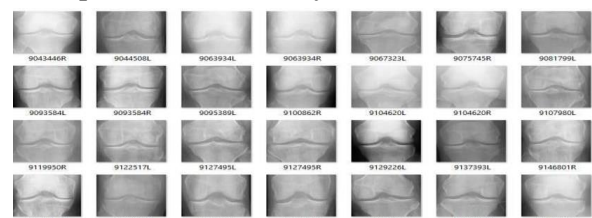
X-rays of Healthy
